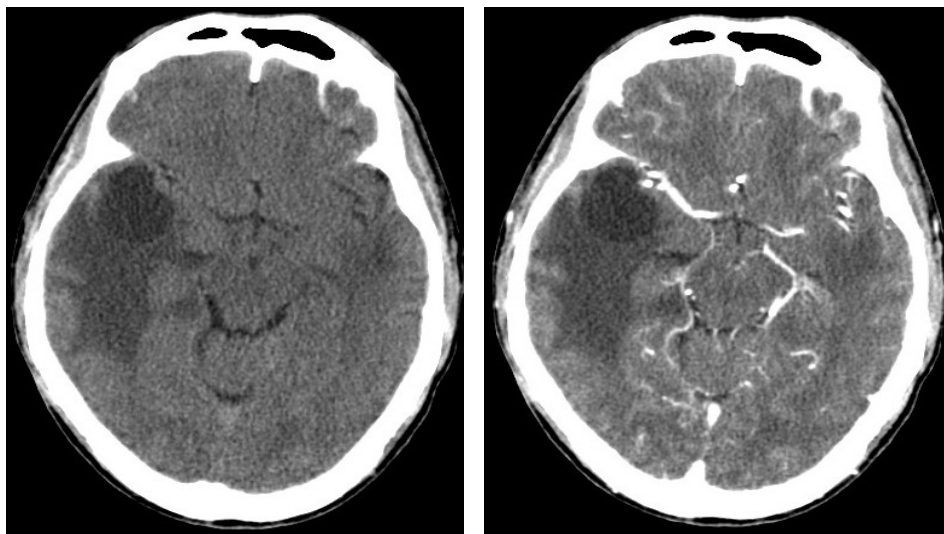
CT findings of a 59-year-old male patient with NPC after radiotherapy for over 10 years. A. cystic liquefactive necrosis of the right temporal lobe with edema around lesions. B. no enhancement.
